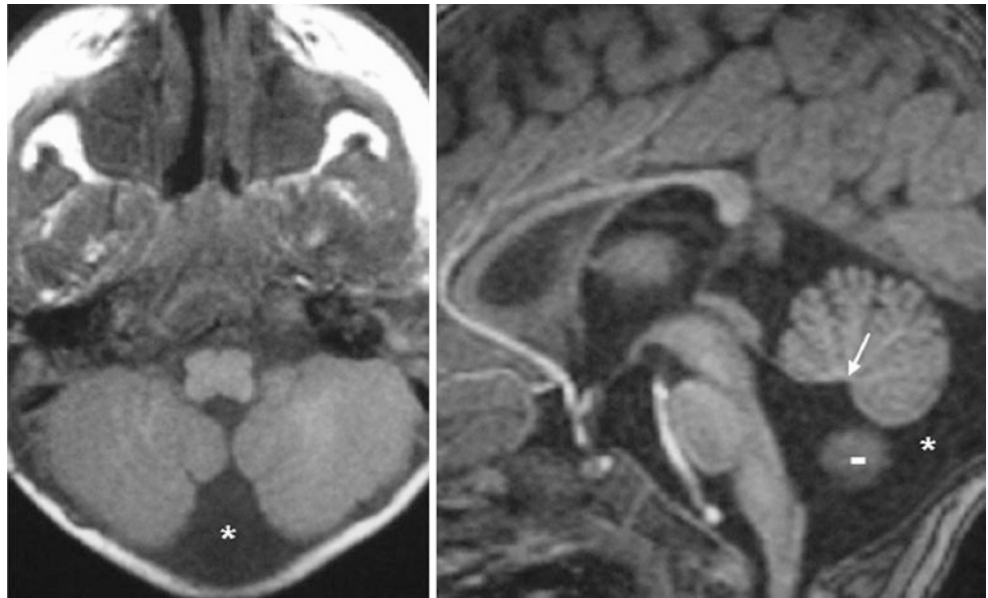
Comparison case of severe CVH. A 35 year old underwent a cervical MRI to check for lymphoma, and the test showed prominent SAS below the vermis (*), an absent posterior angle (fastigium) of the fourth ventricle (arrows), and a hypoplastic pons (!), indicating severe CVH
